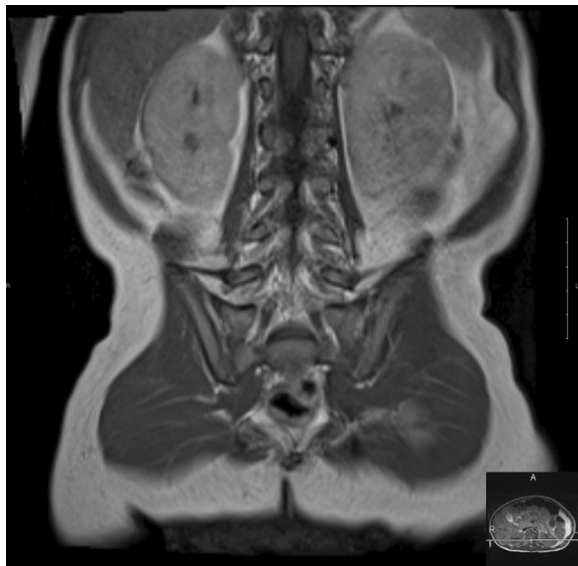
This T1 Coronal MRI displays crescentic lobulated asymmetrical enlargement of the left extraperitoneal intra-abdominal fat with thin septations when compared to the right abdominal wall directly deep to the lateral abdominal musculature
